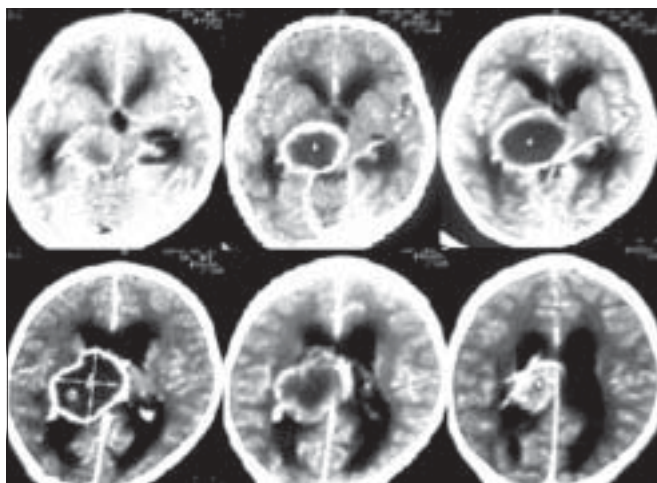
Pre-operative CT scan showing right thalamic abscess with hydrocephalus
